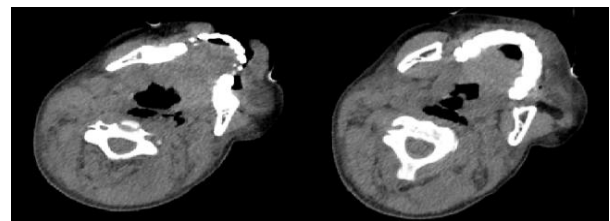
Cervical computerized tomography (CT) scan, showing the laryngeal fracture
